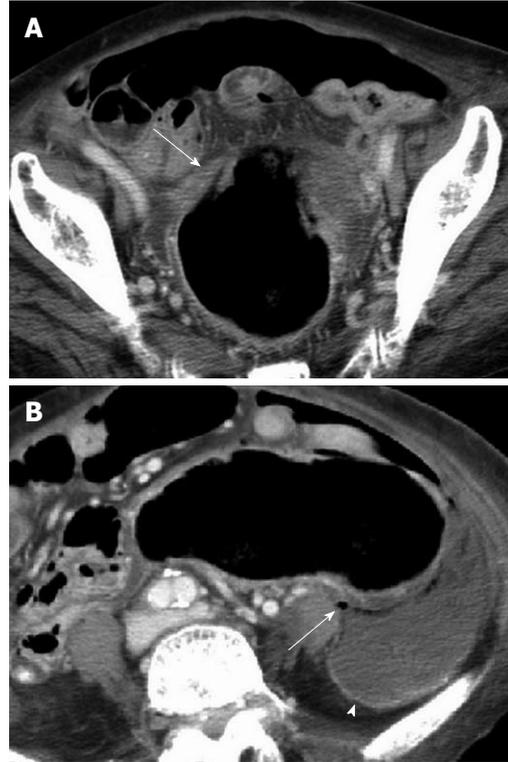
An 88-year-old woman (patient 7) with perforation of the necrotic stercoral colitis at the sigmoid colon. A: An enhanced abdominal computed tomography scan reveals mucosal flap (arrow) slough into the lumen of the colon indicating mucosal sloughing; B: Air pockets (arrow) abutting the colonic wall and pericolic loculated fluid indicative of abscess formation (arrowhead).
